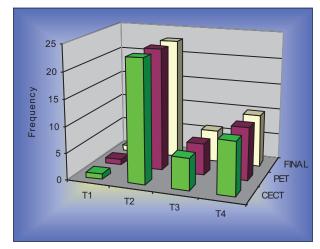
Pretreatment comparison in contrast-enhanced computed tomography and positron emission tomography/computed tomography in detecting T-stage
